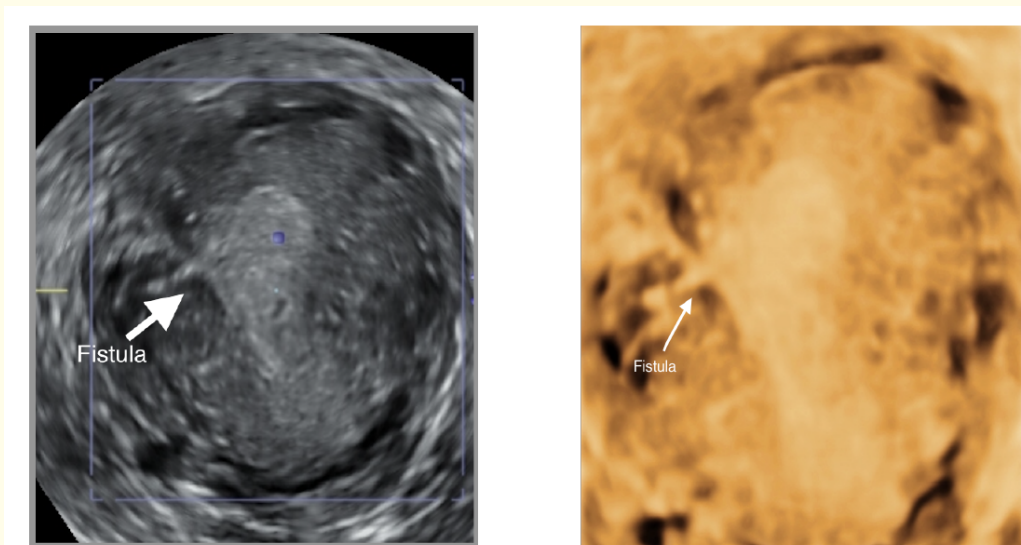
3-D vaginal ultrasound showing a lateral communication between the uterine cavity and the operation site where the myoma was.
